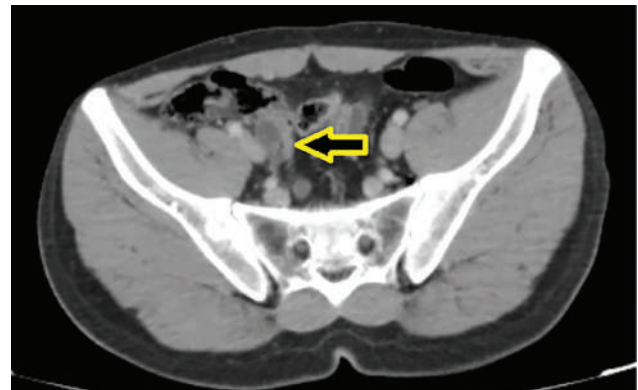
Contrast-enhanced abdominal computed tomography findings.
